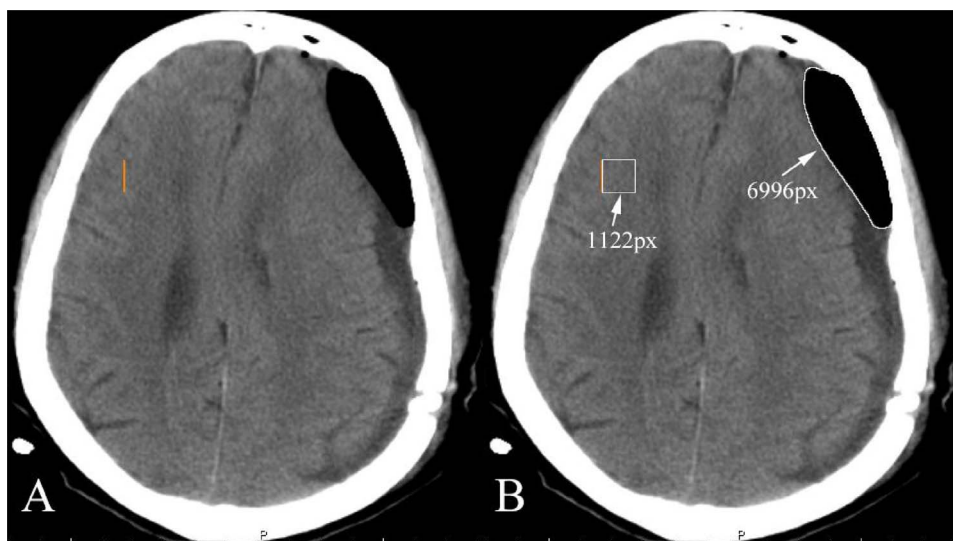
Calculation of the volume of pneumocephalus. A. Using the Uniweb Viewer to draw a 1 cm line on the CT image, which serves as ratio reference between the pixels of CT image and intracranial volume. B. Using GIMP, with the aforementioned 1 cm line as the side, select a square area, through the “histogram” window we can read out the pixel number, which is the CT image pixel number corresponding to 1 square centimeter of the intracranial space, namely, pixel-intracranial space ratio. Then we used the “magic wand tool” to select the pneumocephalus portion on the CT image, and read the pixel number through the “histogram” window, namely, slice pixels of pneumocephalus. Since the thickness of an axial CT slice is 0.6 cm, we can calculate the volume of pneumocephalus of the slice with the following equation: Slice volume of pneumocephalus (ml) = slice pixels of pneumocephalus/pixel-intracranial space ratio * 0.6. The total volume of the whole pneumocephalus can be calculated by adding all the slice volumes.
